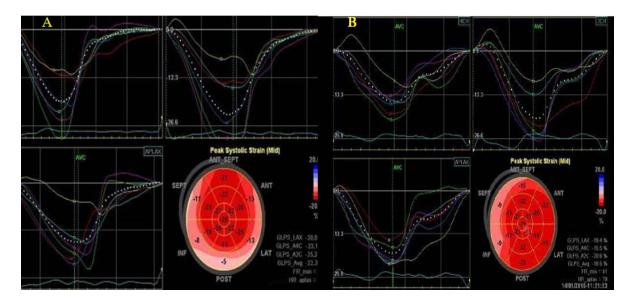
Speckle tracking echocardiography strain curves and Bull's eye of LV GLS of (A) a severe MS case; average GLS = -22.3% and (B) moderate MS case showing average GLS = -18.5%. LV: left ventricular; GLS: global longitudinal strain; MS: mitral stenosis.
